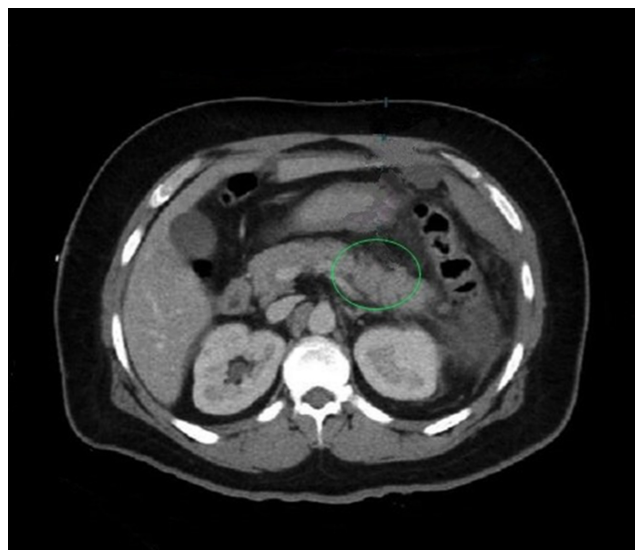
Computed tomographic (CT) scan of the abdomen showing peripancreatic inflammatory changes in the distal pancreas.
